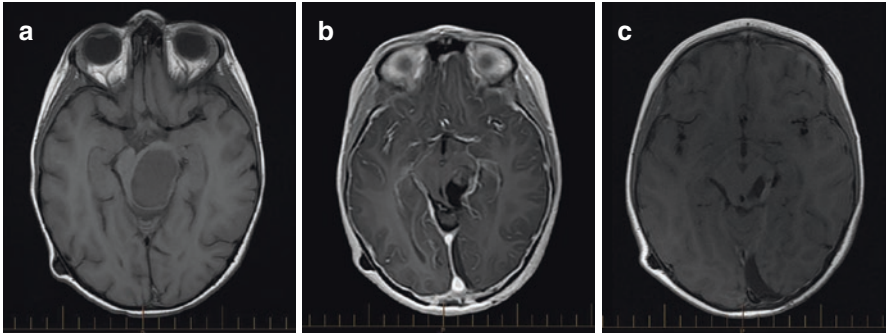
(a) A midbrain JPA in a 6-year-old boy who presented with a right VI nerve deficit and a right hemiparesis. (b) Macroscopic residual disease following initial surgery was resected at a second surgery 2 months after the first. (c) MRI 2 months after the second surgery shows residual signal abnormality in the tumor bed interpreted as possible residual tumor vs. early gliosis. He will continue to be followed with MRI Q3–4 months. If and when there is evidence of progressive tumor, further surgery or systemic chemotherapy would be considered as the next step. Radiotherapy would not normally be considered the best option at this age
